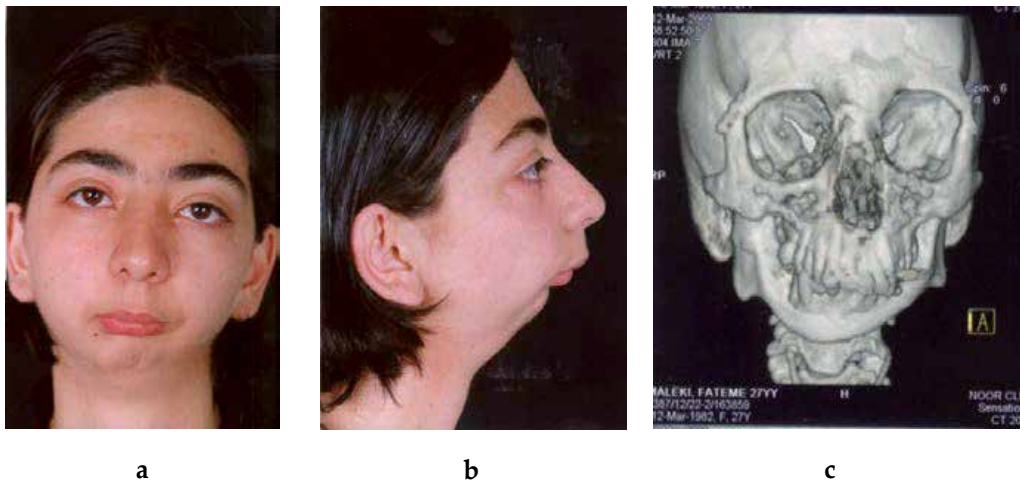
An 18-year-old girl with bilateral condylar ankylosis. a) Long term effect of bilateral condylar ankylosis in a growing adolescent, which result in limited mouth opening, micrognathia and absent neck chin angle. b) The profile view is helpful to assess anteroposterior and vertical facial imbalance as well as aid in the determination of etiology of the asymmetry. c) 3D CT scan.
